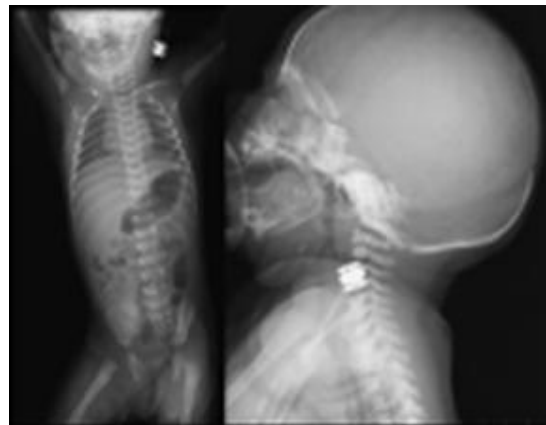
X-ray examinations in anterior-posterior (a) and lateral (b) view. There aren't skeletal abnormalities
